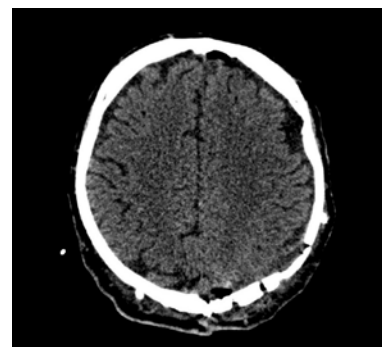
Postoperative computed tomography, axial non-contrast slices. No signs of surgical complications.
